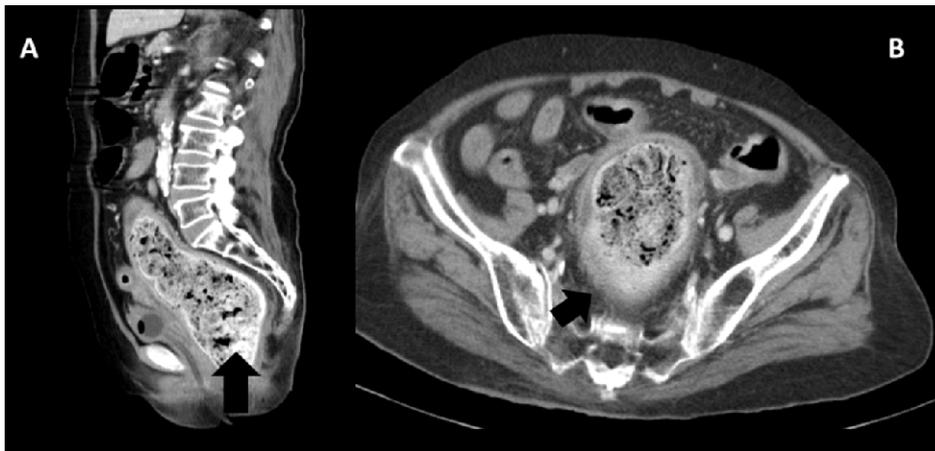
Computed tomography of abdomen revealed fecaloma (arrow) in the rectum (A), with inflammatory rectal wall and peri-rectal fat stranding (arrow) (B).
